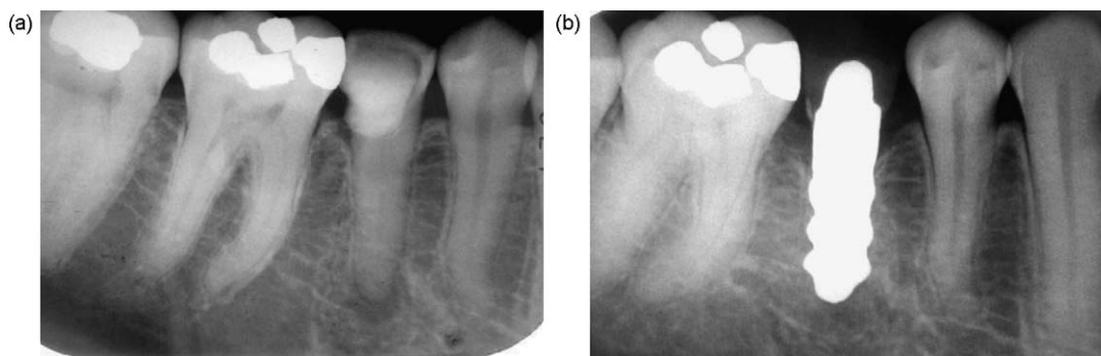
(a) X-ray before extraction. (b) X-ray at 15 months follow-up with the zirconia implant and crown in situ.
